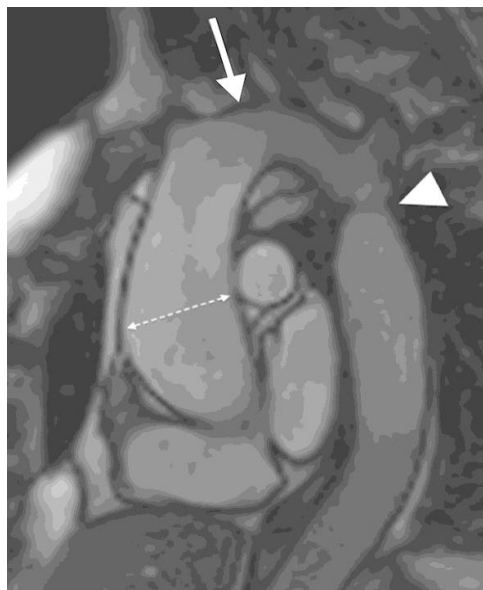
MRI aortic coarctation of descending thoracic aorta (white arrowhead)<sup>(26)</sup>
